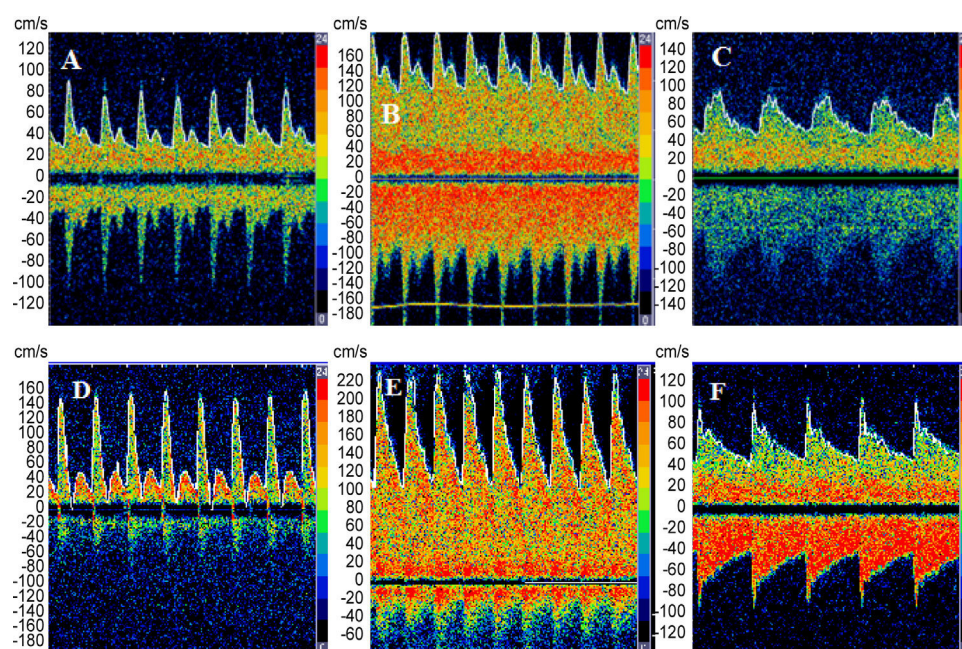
Transcranial Doppler: (A) before liver transplant; (B) 1st day after transplant; and (C) 3rd day after liver transplant; (D) 4th day after transplant; (E) 5th after transplant and (F) 7th after transplant.
